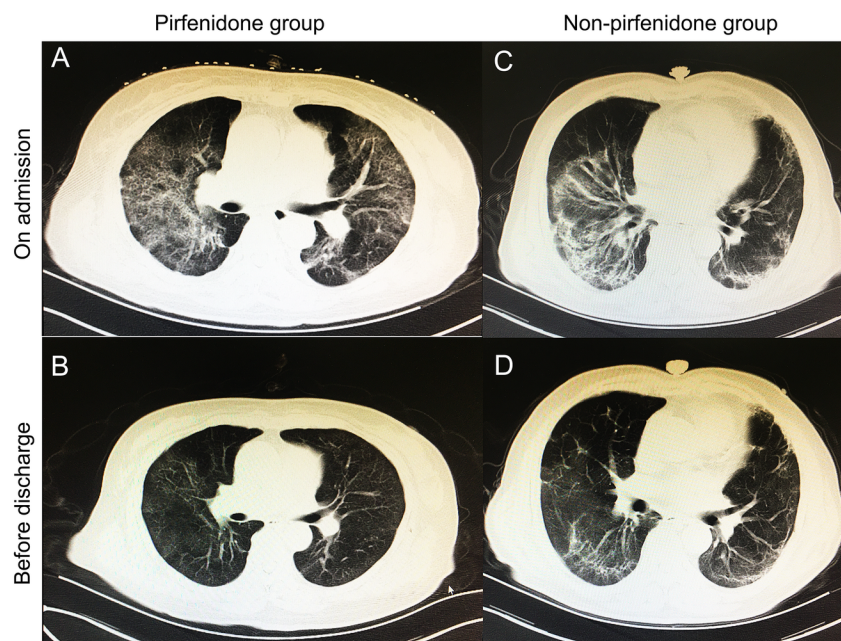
Chest CT of patients with COVID-19 after pirfenidone therapy. (A) CT scan image on admission in a patient with pirfenidone treatment. (B) 30 days later before discharge, the CT scan in patient (A), the GGO was obviously absorbed; (C) CT scan image on admission in a patient with non-pirfenidone treatment; (D) 30 days later before discharge, the CT scan in patient (C), the GGO was partially absorbed and the fibrous stripes/crazy-paving sign had no significant changes. GGO=ground-glass opacity; COVID-19=coronavirus disease 2019; URL=upper range limit.
